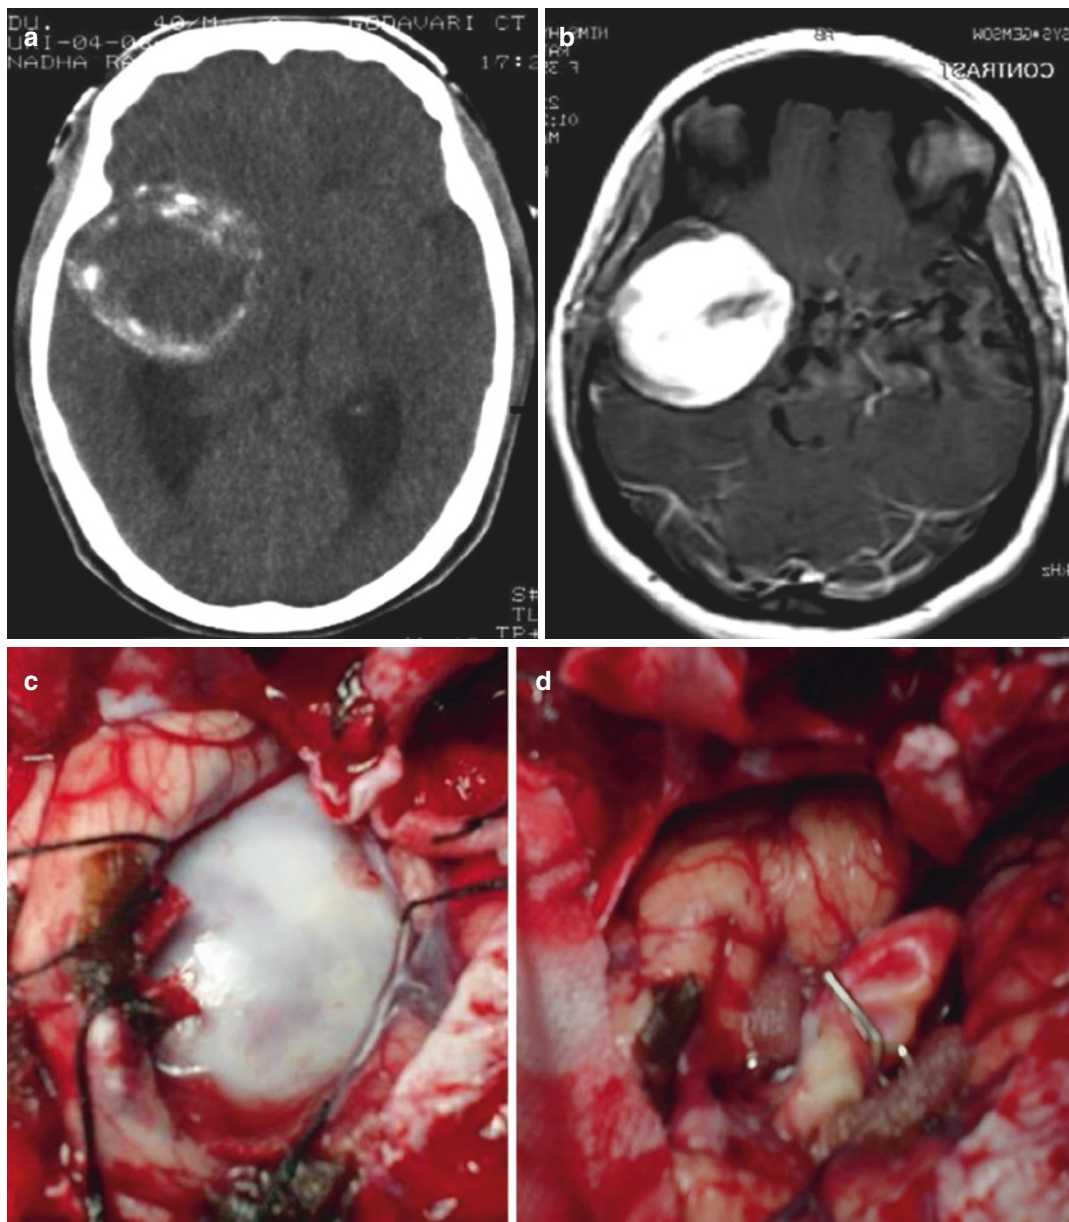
(a–e) Aneurysms with mass effect: (a, b) Giant aneurysm with mass effect as seen in the CT scan axial section. (c) operative pic of a giant aneurysm. (d) Giant
